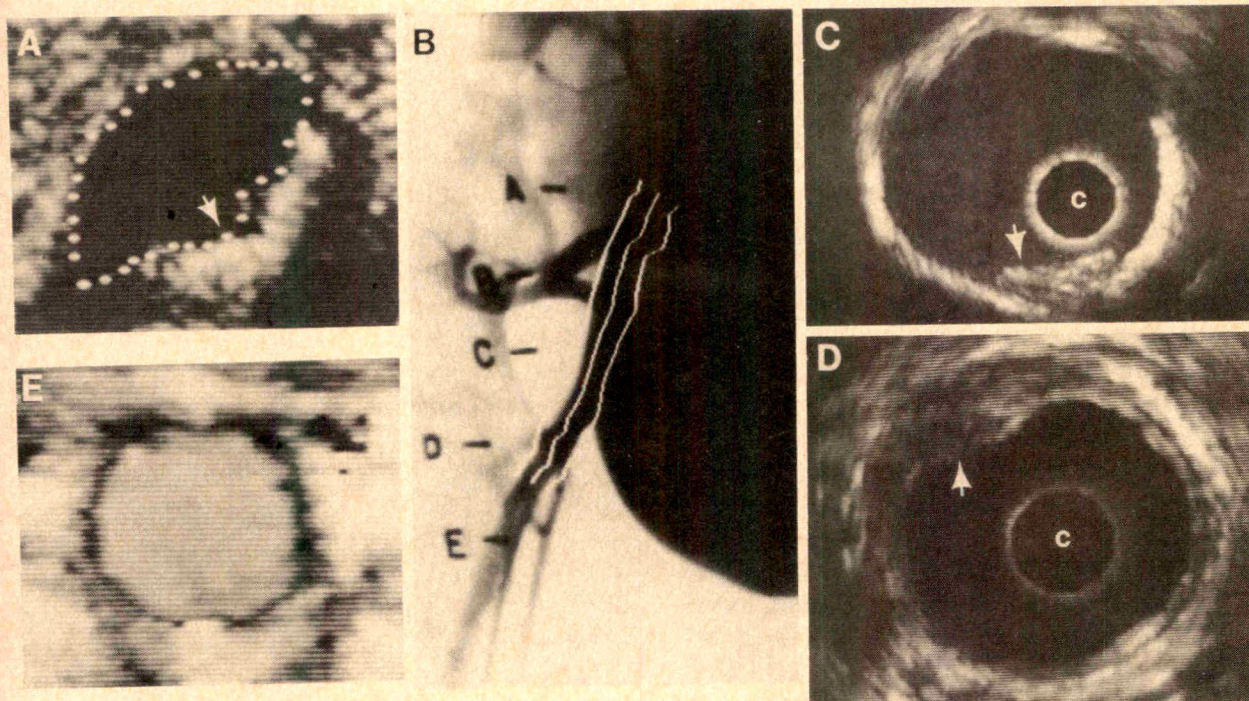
Representative images from all vascular imaging modalities. Clockwise from upper left: A, 2-dimensional external ultrasound image of site marked "A" on the angiogram (B). The arterial lumen is echo-free, and is outlined by the dotted line to determine luminal cross-sectional area. Arrow, hard plaque demonstrating hyperechoicity and acoustic shadowing. B, digital angiogram of the right common femoral artery. Imaging points "A through E" indicate surface radiopaque markers. C, intravascular ultrasound image from site "C" on the angiogram (B). Arrow, hard plaque demonstrating hyperechoicity and acoustic shadowing. Catheter blank spot (c) is within the echo-free arterial lumen. D, intravascular ultrasound image taken from site "D" on the angiogram (B). Arrow indicates soft plaque. E, Doppler color-flow external ultrasound image of site "E" on the angiogram (B). Shaded area, representing the color Doppler signal, is the vessel lumen.
